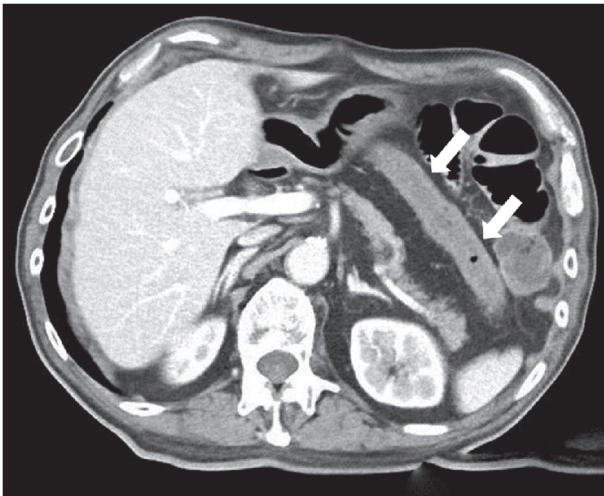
Abdominal contrast-enhanced computed tomography findings. Ischaemia was observed from the transverse colon to the descending colon (arrows).
